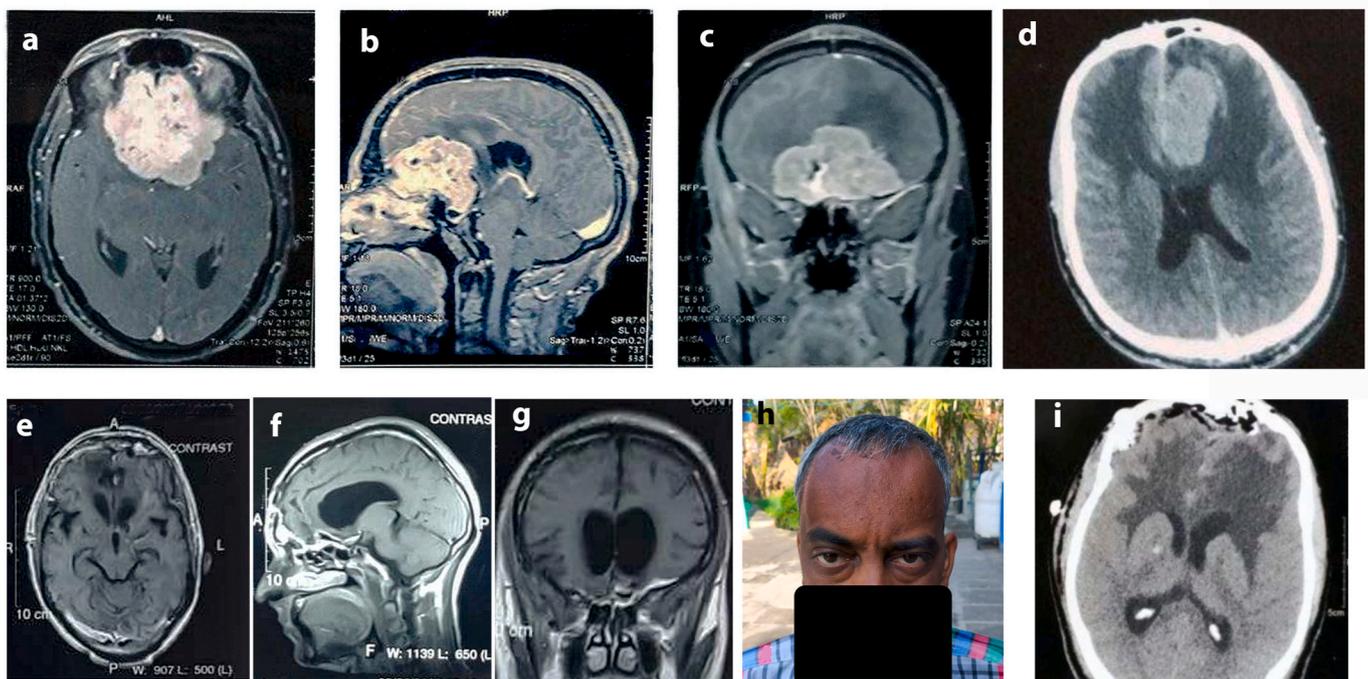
(a,b,c) preoperative axial, sagittal and coronal contrast images showing a large anterior cranial fossa meningioma (e,f,g) postoperative radiology at follow up showing complete resection of tumor. (h) post-operative cosmetic outcome in right sided unilateral extended frontal approach. Olfaction was preserved in the post-operative period and the personality changes improved (d, i) pre-operative CT head showing the lesion with significant perilesional edema, and post-operative scan showing the lack of frontal contusions post-procedure with no increase in brain edema.
